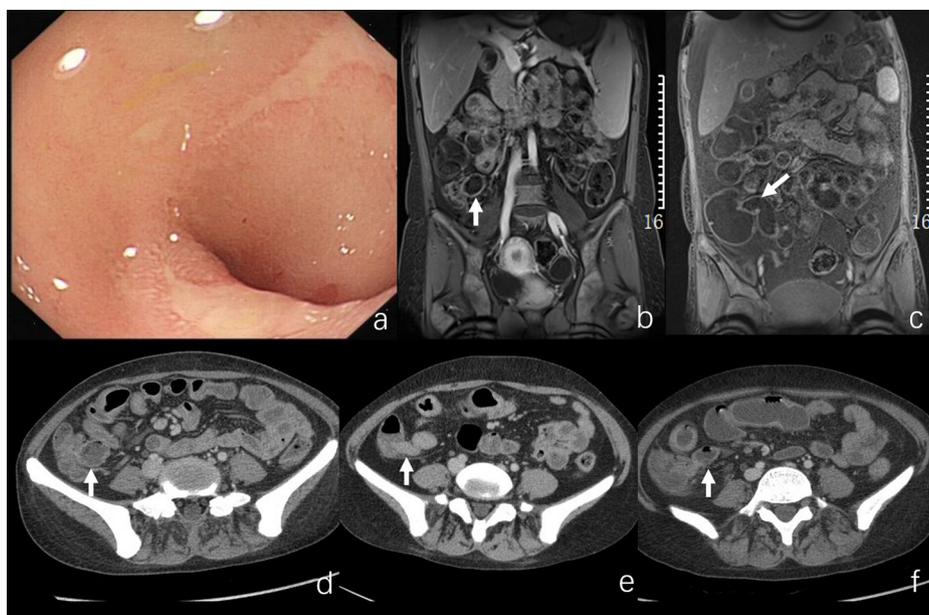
Barium meal radiography (a) showing the thickened intestinal mucosal folds and stenosis of the ileum. Coronal post-contrast T1 weight imaging (b and c) and axial post-contrast imaging (d-f) at five different time points showing the uniform thickening of small bowel wall (arrow), “clear” mesentery (star) and enlarged nodes (arrow head). The imaging findings at different time points are similar.
